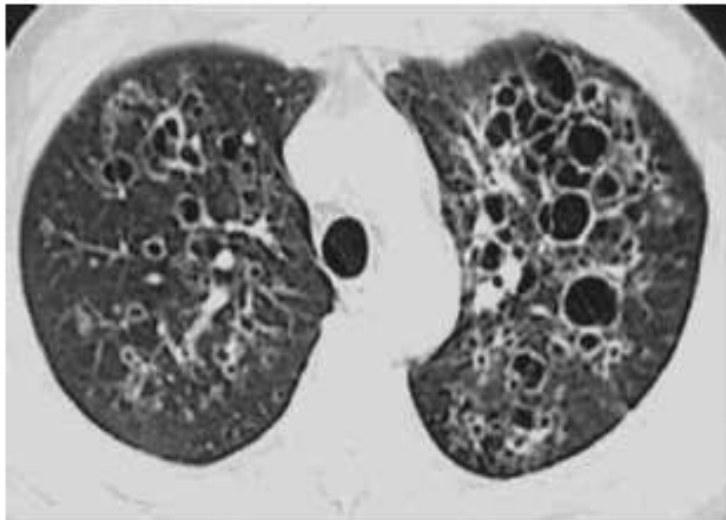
Cystic PJP on HRCT: cystic images in upper lobe and bilateral peripheral small nodules.
